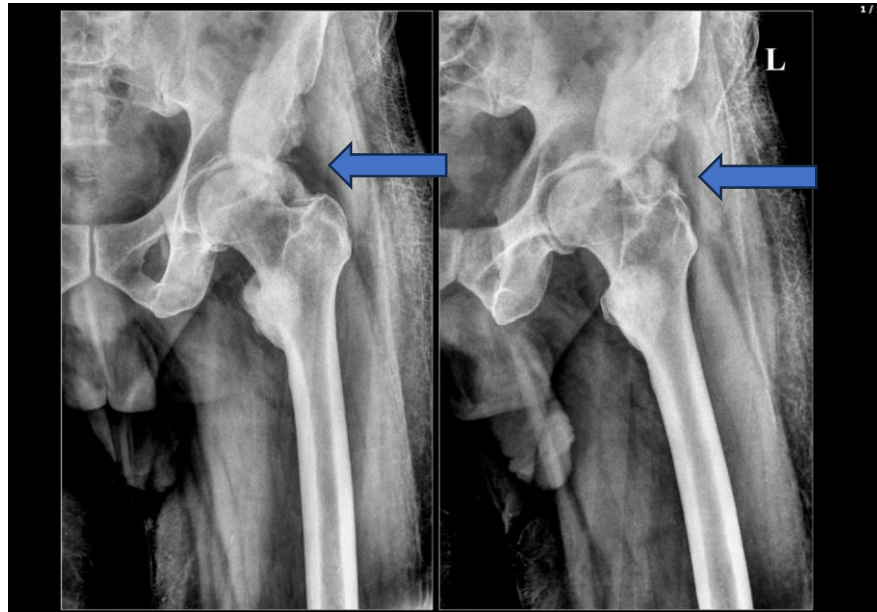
Bedside X-ray of the Left hip AP of Case 3
